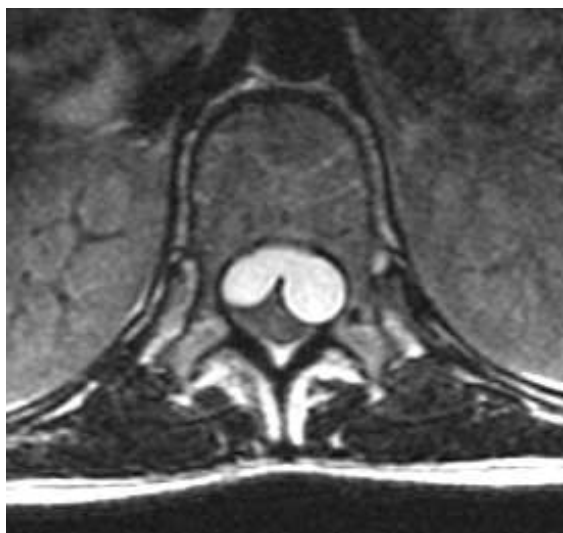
Pre-operative second MRI after neurological deterioration – Axial
